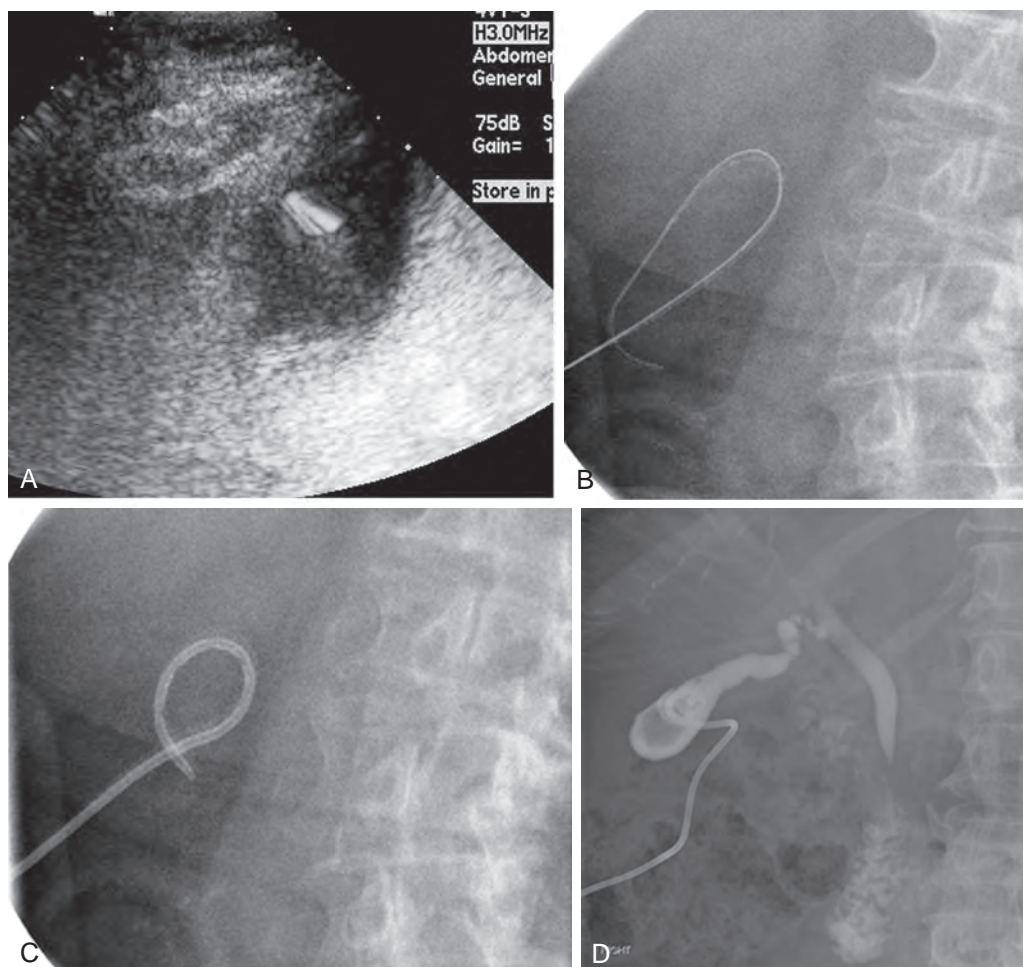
Percutaneous cholecystostomy. A. Ultrasound confirms position of needle in the gallbladder. B. Placement of a guidewire in the gallbladder. C. Placement of 8F pigtail drain in the gallbladder. D. Tube check several days later confirms a gallstone in the gallbladder and patency of the cystic duct. The tube was capped, and the patient had a cholecystectomy.
